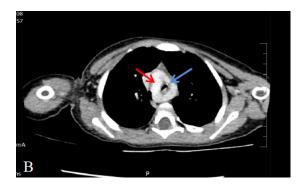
Coronal CT images showing (R) sided dominant aortic arch (Red arrow) and (L) sided small arch (blue arrow)
